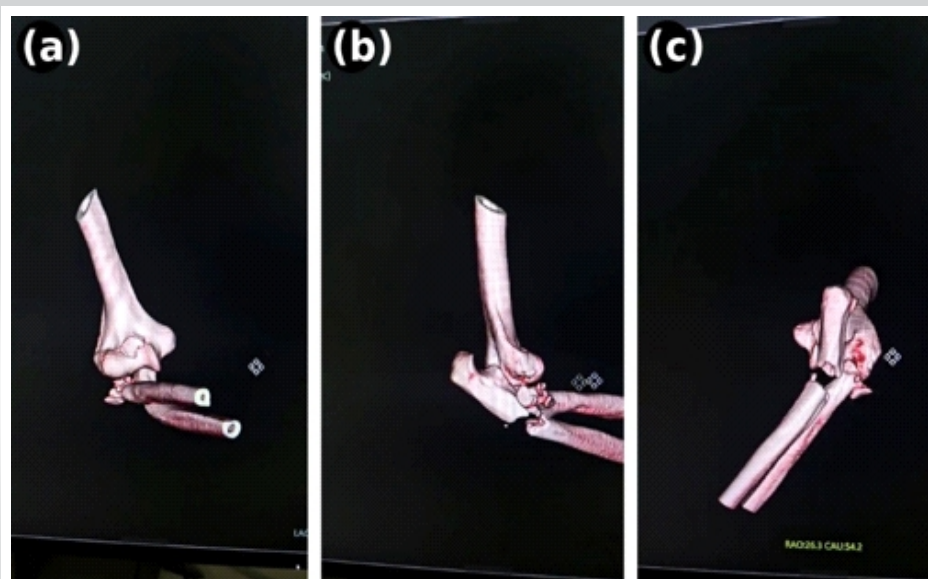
Three-dimensional computed tomography reconstructions confirming all four components of the “terrible tetrad.” (a) Anteroposterior view demonstrating posterior dislocation and comminuted radial head fracture. (b) Posterior view showing the ulna fracture and radial head fracture dislocation. (c) Oblique view delineating the coronoid process fracture and overall injury configuration.
